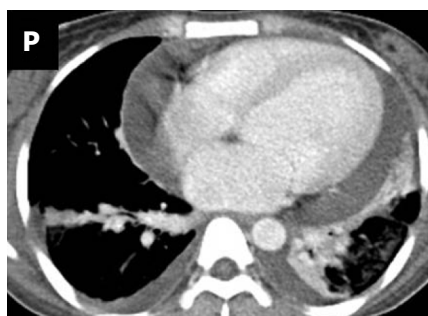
Computed tomography findings in children (less than 10 years), adolescents (10-18 years), and adults (above 18 years) with chest tuberculosis. A-F: Children; A: Parenchymal consolidation in right lung with adjacent thick walled cavities; B: Multiple cavities with adjacent fibrosis in right upper lobe; C: Tiny low density centrilobular nodules seen diffusely in both lungs; D: Fibrobronchiectatic changes in right middle and lower lobes; E-F: Enlarged low attenuating necrotic nodes in right paratracheal, and right hilar location respectively; G-J: Adolescents; G: Parenchymal consolidation with centrilobular nodules in left lung, nodules in right middle lobe; H: Thick walled cavities with surrounding consolidation and air space nodules in both upper lobes; I-J: Pleural based fibrotic changes with calcification in right upper lobe with necrotic right paratracheal node; K-P: Adults; K: Multifocal consolidation in right upper lobe; L: Thick walled cavities in right upper lobe; M: Miliary TB- multiple tiny nodules distributed randomly in both lungs; N: Fibrobronchiectasis in right middle lobe with nodules in left lower lobe; O: Necrotic right paratracheal node with empyema in left side; P: Pericardial and bilateral pleural effusion.
